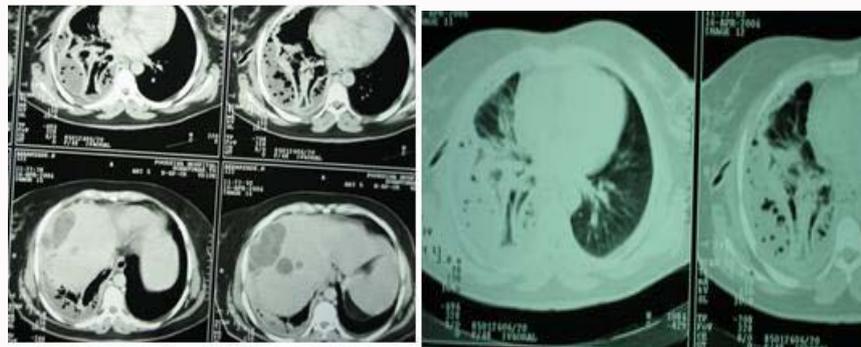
CT scan of chest showing pleural effusion with multiple air space lesion on the effusion, collapse of right lower lobe and chest-tube.
